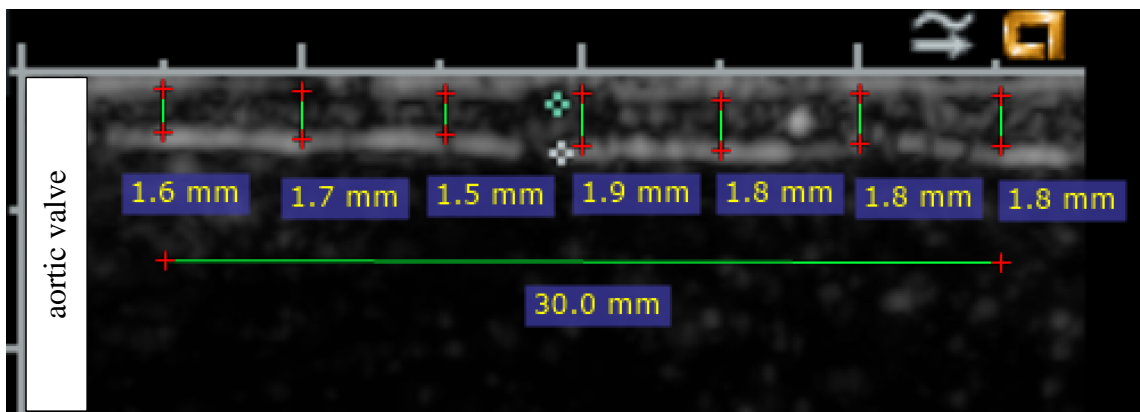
Aortic wall thickness at the ascending aorta obtained from the ultrasound machine.
